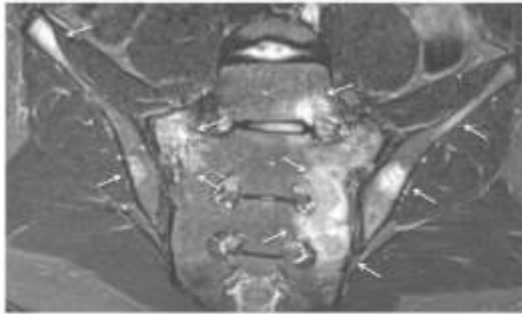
Semicoronal STIR MR images in a 13-year-old boy. Diffuse areas of bone marrow edema (arrows) are present. This patient was ultimately diagnosed with Hodgkin lymphoma.
